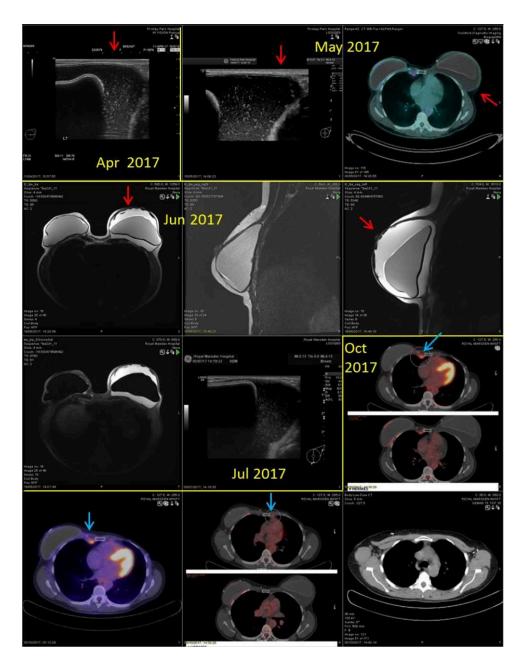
CASE 7 - 50-year-old lady. In 2010 she had had left breast cancer (HER2 positive, BRCA carrier): a 9-mm nodule of grade 3 intraductal carcinoma, ER8, PR7, and HER2 highly positive alongside a mass of 8 cm intermediate/high grade ductal carcinoma in situ. She was treated with left mastectomy and implant/acellular dermal matrix Mentor 350 cm3 low height high profile. In 2011 she underwent to a right mastectomy with implant/acellular dermal matrix and received multiple revisions due to seroma. The final implant was 350 cm3 polyurethane. In February 2017 she presented with swollen left breast reconstruction and discolouration to lower half skin paddle. IMAGING: In May 2017 an outside PET/CT scan demonstrated a large seroma (red arrow) surrounding the left-sided breast implant. Low-volume right internal mammary chain (light blue arrow) and axillary nodal tissue was documented. However, this was entirely non-specific, considering that small ipsilateral internal mammary chain lymph nodes are often observed
